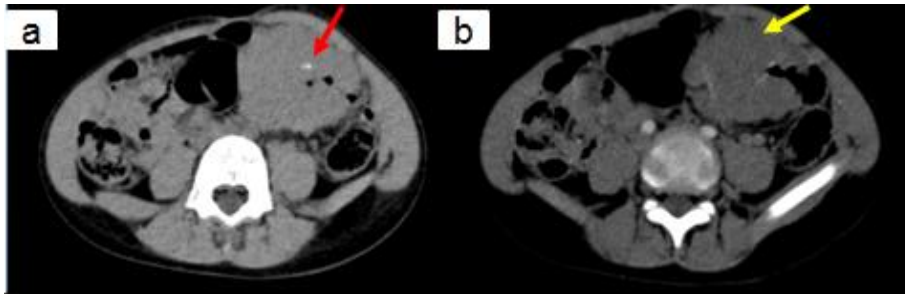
CT scan without (a) and with contrast (b) shows marked thickening of the sigmoid wall (yellow arrow) with phleboliths (red arrow)
